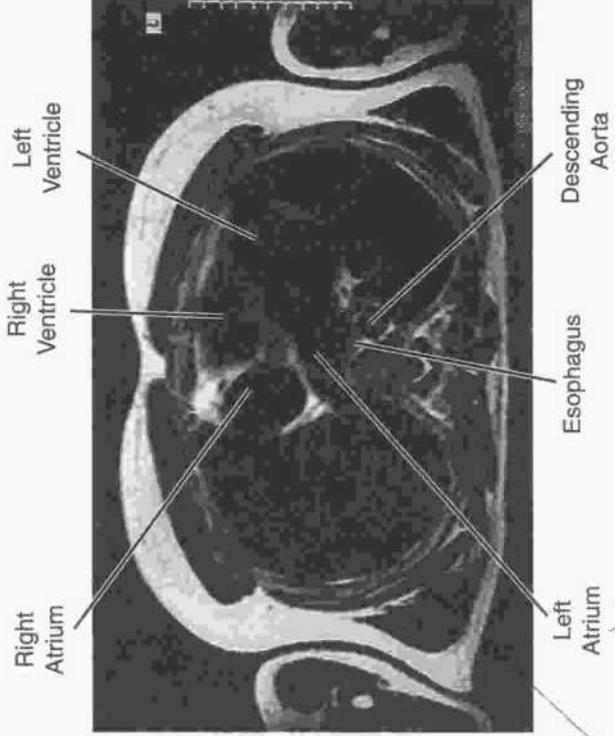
Chest: MRI, Axial T₆
